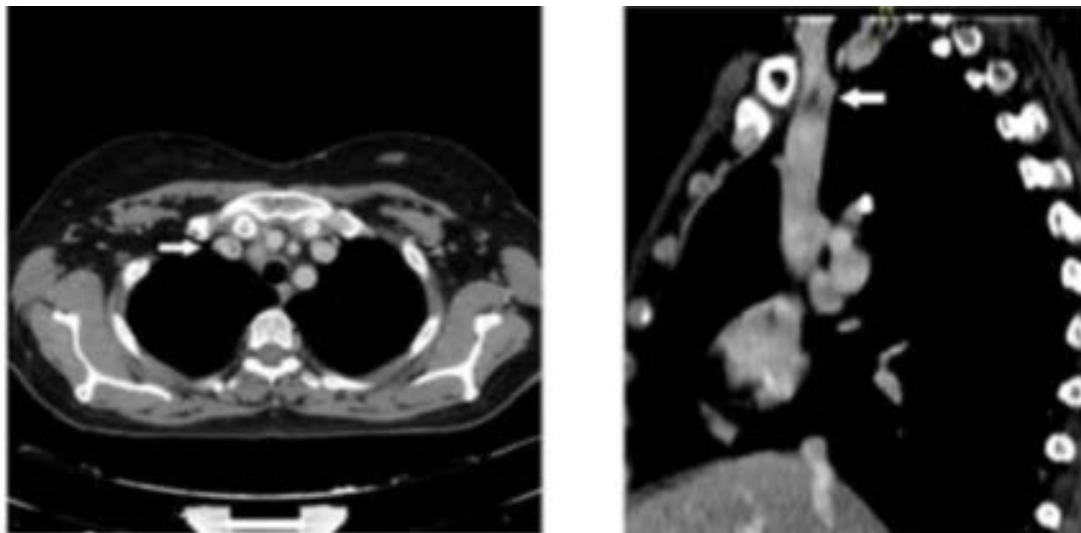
CT scan performed after one year of anticoagulant treatment, confirming presence of free-floating formation of 8 mm in the right innominate vein, A: Axial scan; B: Sagittal scan.
